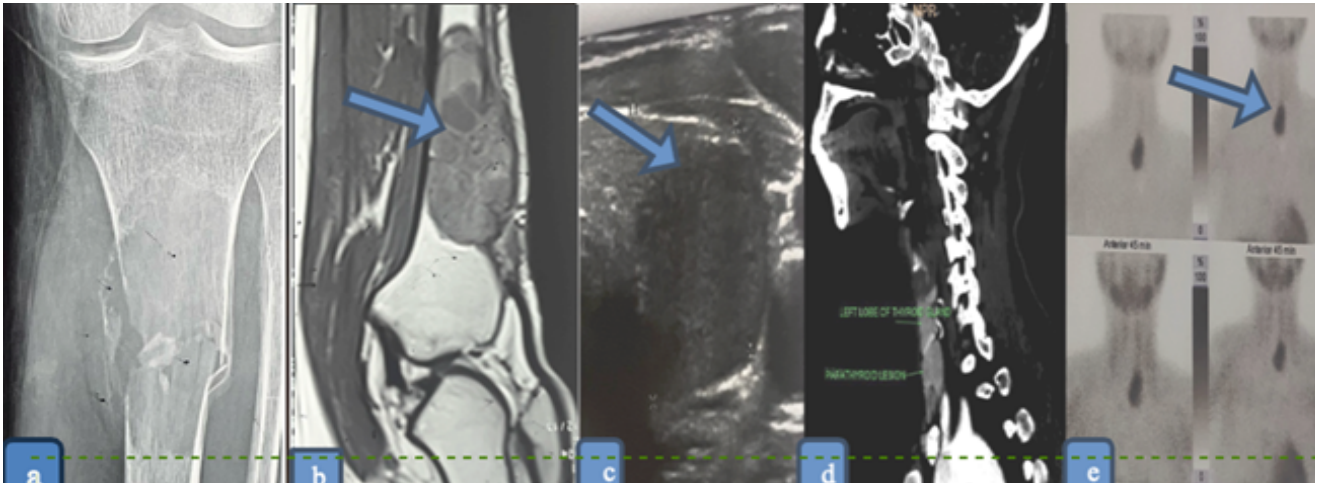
Expansile lytic lesion with pathological fracture of tibia (a). The lesion shows heterogeneous enhancement with enhancing septa (b). Ultrasonography of neck shows well defined homogeneously hypoechoic lesion at inferior pole of thyroid gland (c). Sagittal (d) contrast-enhanced computerized tomography neck showing well-defined heterogeneously enhancing lesion inferior to left lobe of thyroid gland. 99 m Tc - MIBI Parathyroid Scintigraphy showing uptake of radiotracer at the inferior aspect of left thyroid lobe.
